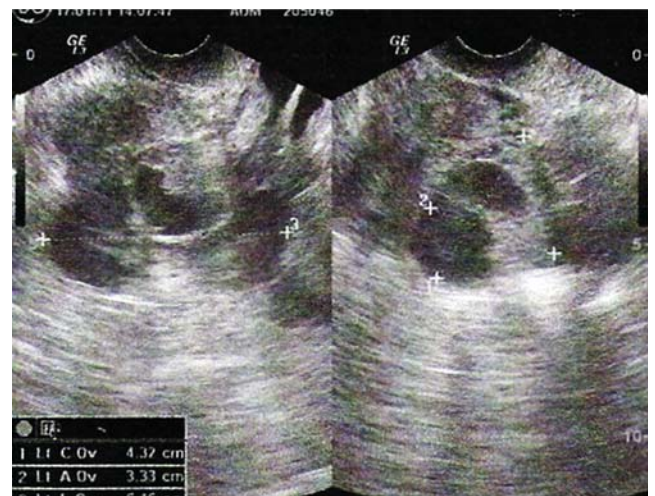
Transvaginal ultrasound showed left adnexal region with heterogeneous hypoechoic lesion with cystic and solid components
